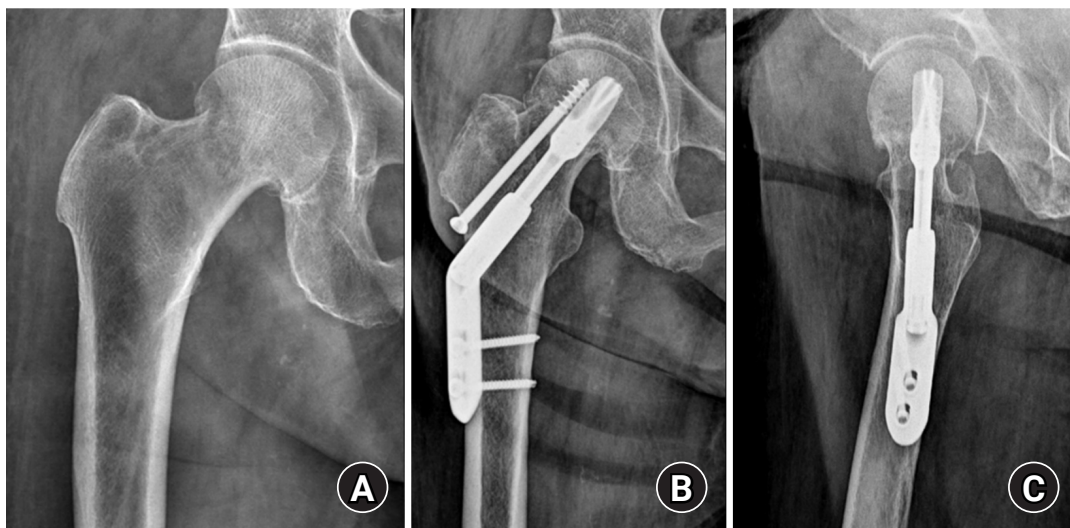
(A, B) An 86-year-old female patient with a stable right femoral neck fracture treated with a dynamic hip system. (C) Postoperative 1-year anteroposterior and axial radiographs show a well-healed fracture site and no complications related to the implant.
